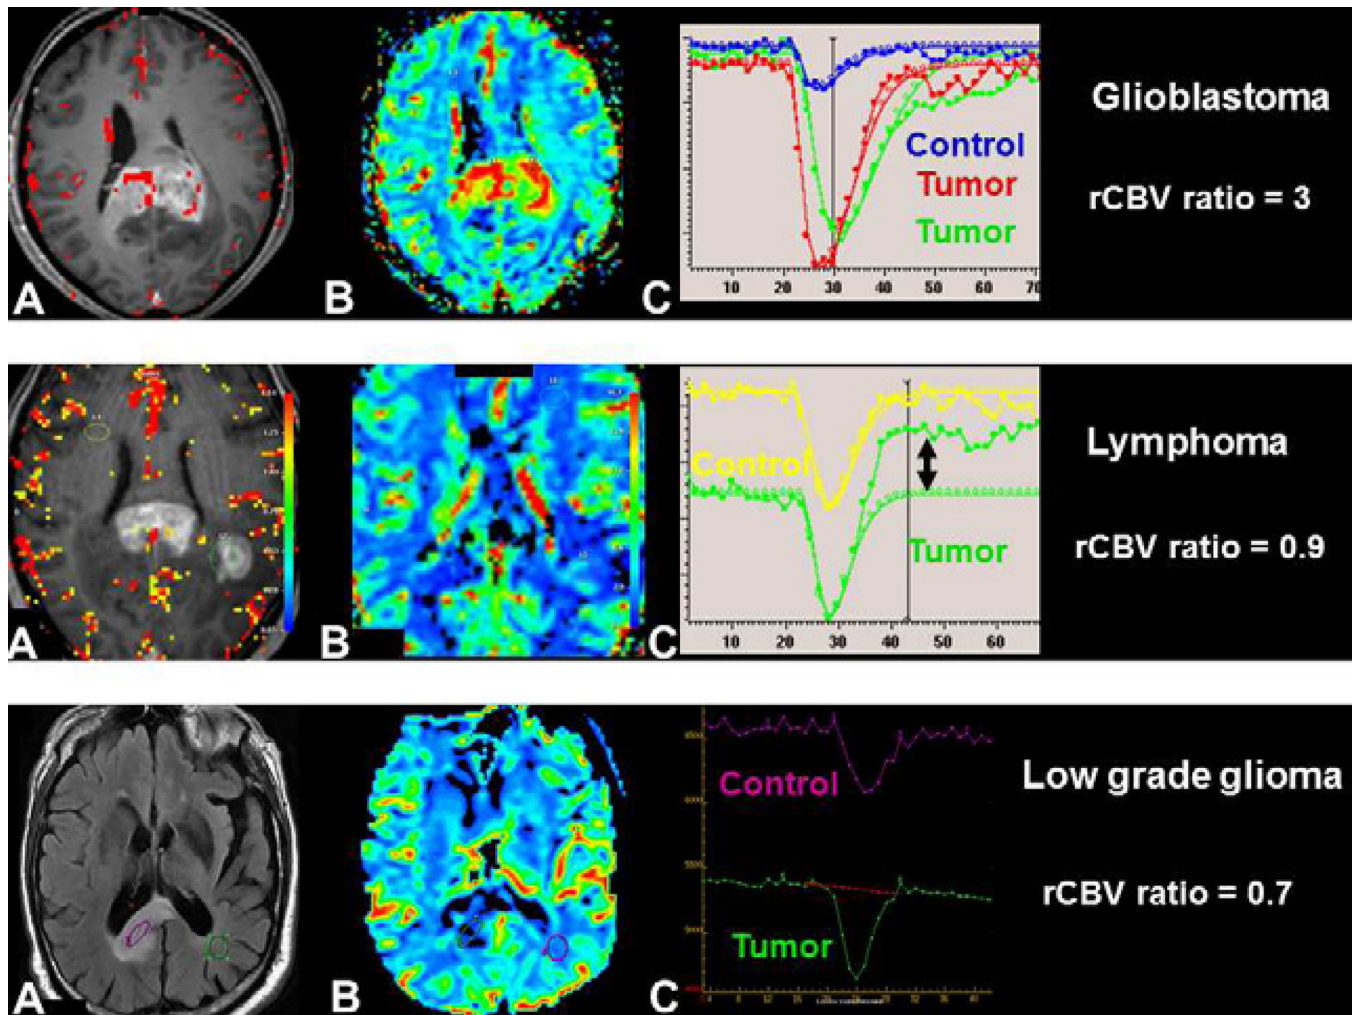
Differentiation of brain tumors involving the corpus callosum using DSC-MRI: glioblastoma (upper row), primary CNS lymphoma (middle row) and low-grade glioma (lower row). Contrast enhancement within the tumor seen on axial T1-weighted image post-gadolinium does not discriminate glioblastoma (A) from and lymphoma (D). rCBV color maps demonstrates increased perfusion within glioblastoma(B), but not within lymphoma (E). The rCBV ratio - tumoral rCBV /normal brain rCBV- is elevated (>1.75) for glioblastoma and low for lymphoma. The non-enhancing low-grade glioma, seen with increased signal on FLAIR images (G) has decreased perfusion on rCBV map (H) with a low rCBV ratio. Visual inspection of the curve demonstrates a high percentage signal recovery within lymphoma (F-double arrow), not visible for low grade glioma (I).
